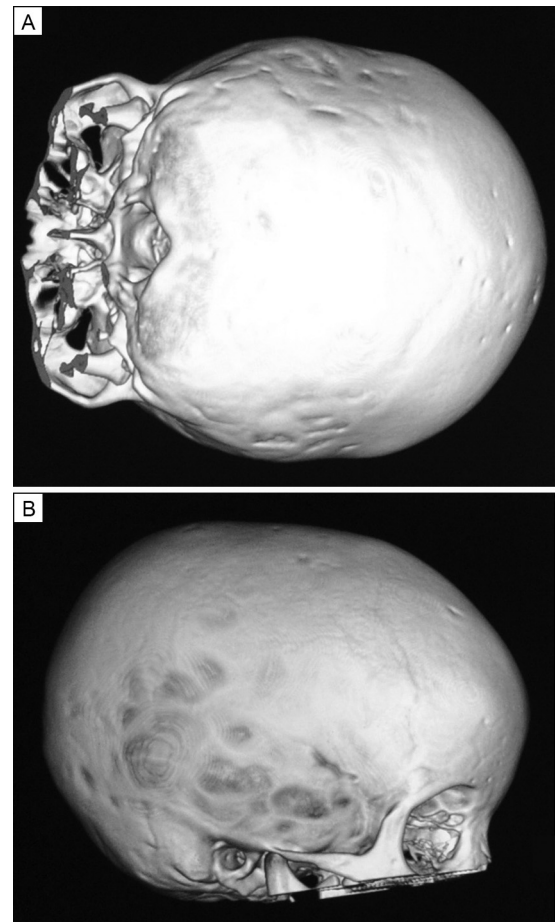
Superior (A) and lateral (B) views of the calvarium on 3D computed tomography scan demonstrating suture fusion and lacunar skull.
